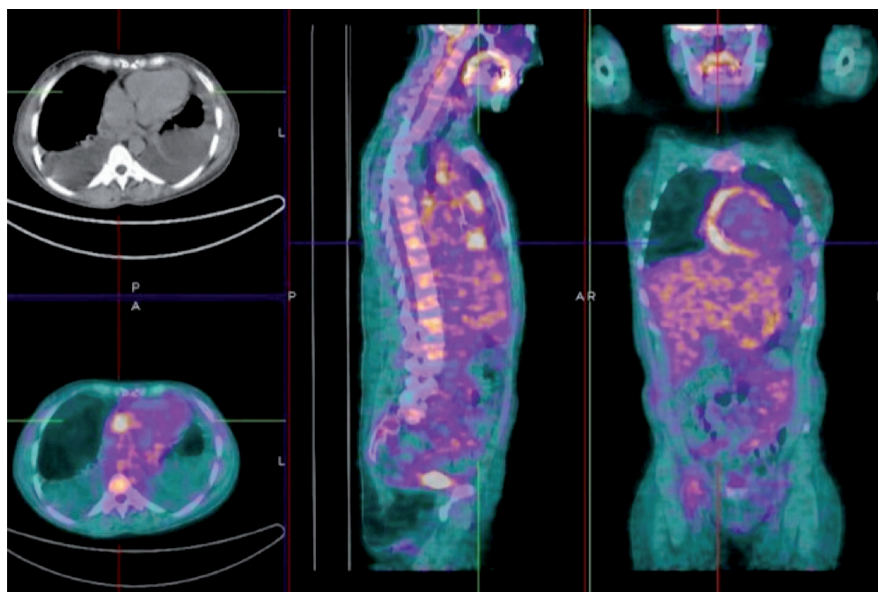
Evidence of clear pericardial uptake with a high SUV at positron emission tomography.
